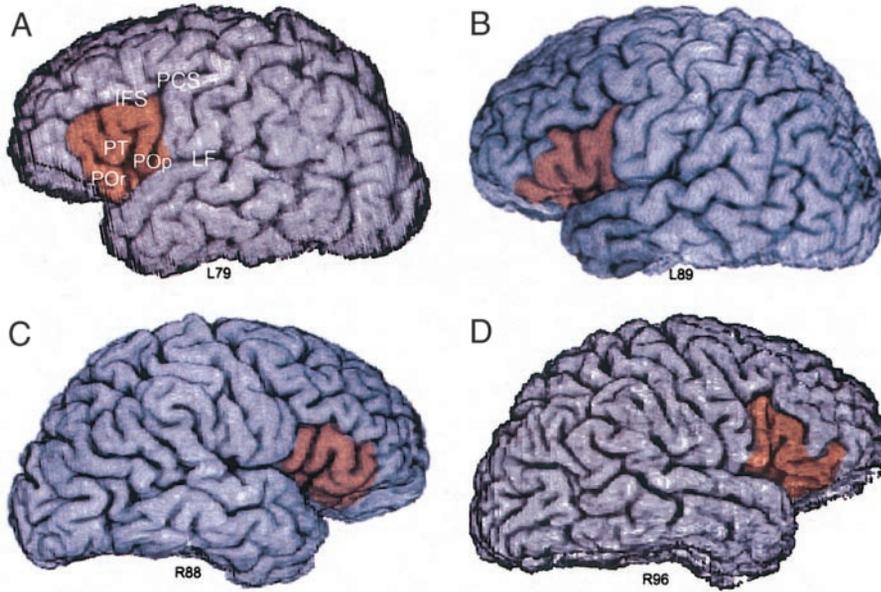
Lateral 3D brain MRI reconstructions of 4 experimental subjects. A: classical configuration of 3 subgyri in the inferior frontal gyrus (IFG) (shaded in orange) and the sulci demarcating the IFG. B–D: variability in the gross anatomic configuration of the IFG. PCS, precentral sulcus; LF, lateral fissure; POp, pars opercularis; PT, pars triangularis; POr, pars orbitalis.
